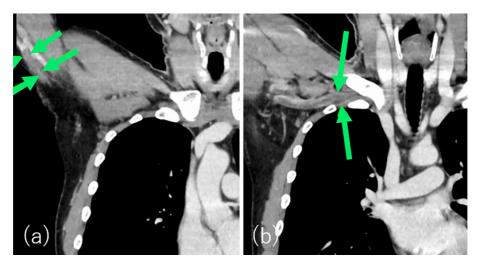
(a) Contrast-enhanced computed tomography (CT) showing occlusive thrombus in the right axillary vein (R-AV). (b) Contrast-enhanced CT showing occlusive thrombus in the right subclavian vein (R-SCV).
